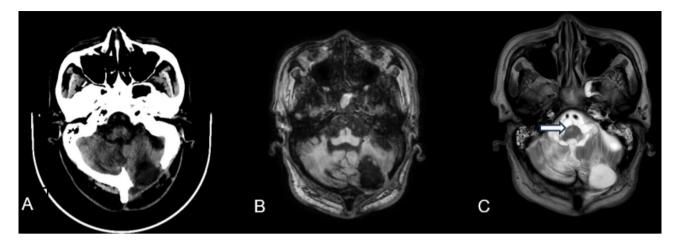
Imaging manifestations; (A) Head CT indicated postoperative left cerebellar hemorrhage; (B) T1 and (C) T2 show bilateral cerebellar softening foci, White arrows in (C) indicate the abnormal inferior olive hypersignal
